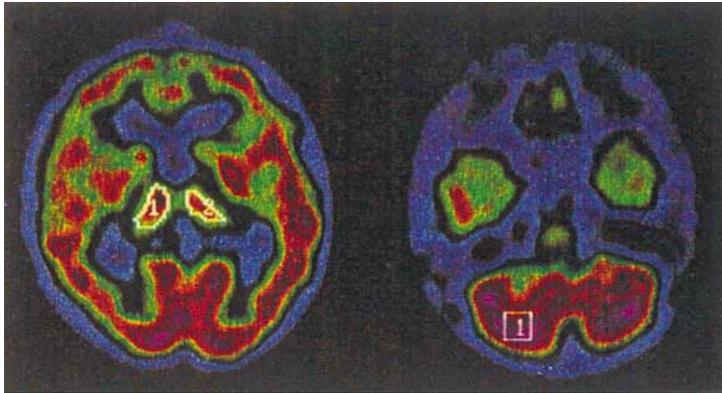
SPECT scan transverse section for rCBF measurement. We measured the rCBF of the thalamus before and after ECT using a ^{99m}Tc -ECD SPECT scan at the level of the basal ganglia, which is parallel to the OM line 5 cm above OM line. ROI template placed on the thalamus and cerebellum on the selected transaxial SPECT image.
